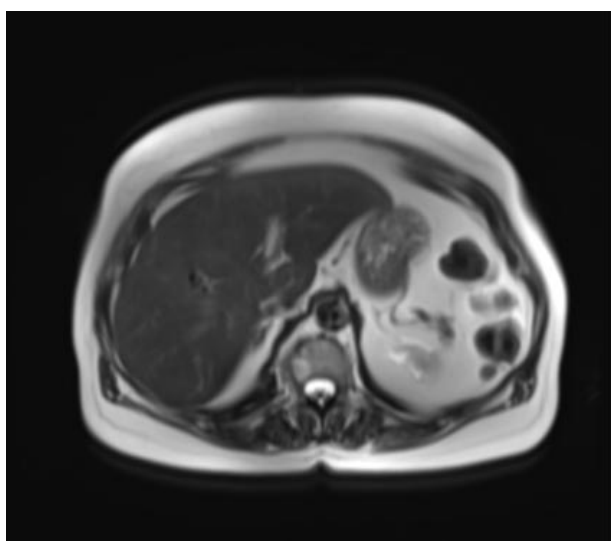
Two irregular hyperdense lesions observed in the liver. Magnetic resonance imaging (MRI). The authors' collection.
